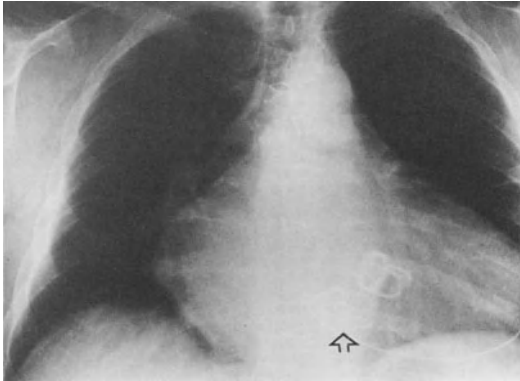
X-ray of the chest demonstrating gross right atrial enlargement as the result of an obstructed tricuspid valve prosthesis in a patient with mitral and tricuspid valve replacement. The right atrial dimension extends from the tricuspid valve prosthesis (arrow) to the right cardiac border.
